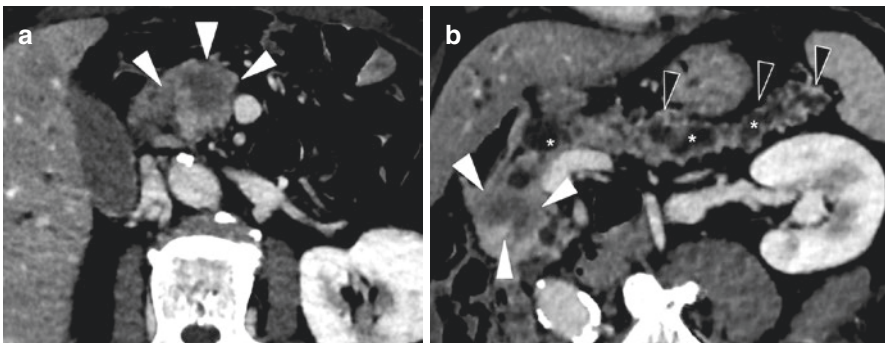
Direct CT signs of pancreatic adenocarcinoma. CT with contrast injection at the pancreatic arterial phase, axial views (a and b) showing a hypoattenuating mass in the pancreatic head (white arrowheads) with parenchymal atrophy (black arrowheads) and upstream dilation of the main pancreatic duct (asterisks)
